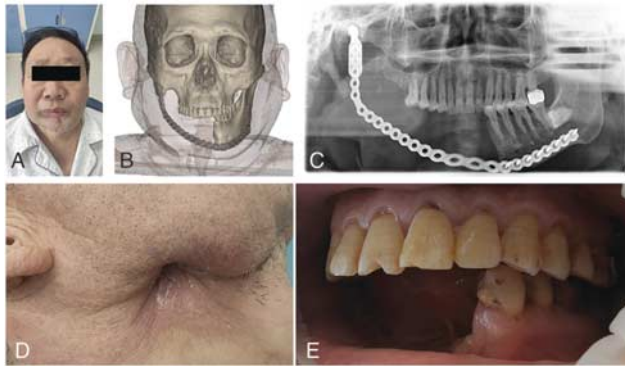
A, Preoperative frontal view. B, Preoperative computerized tomography (CT) reconstruction. C, Full-orifice curved plate. D, The lesions area. E, Occlusal condition.
